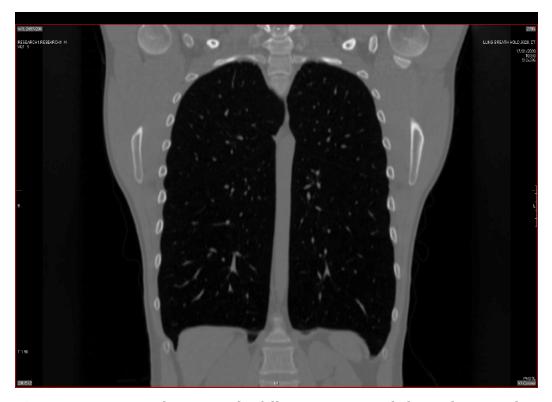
Computed tomography following a maximal glossopharyngeal insufflation manoeuvre. A flattening of the central part of the diaphragm with accentuated costophrenic angle is evident.
